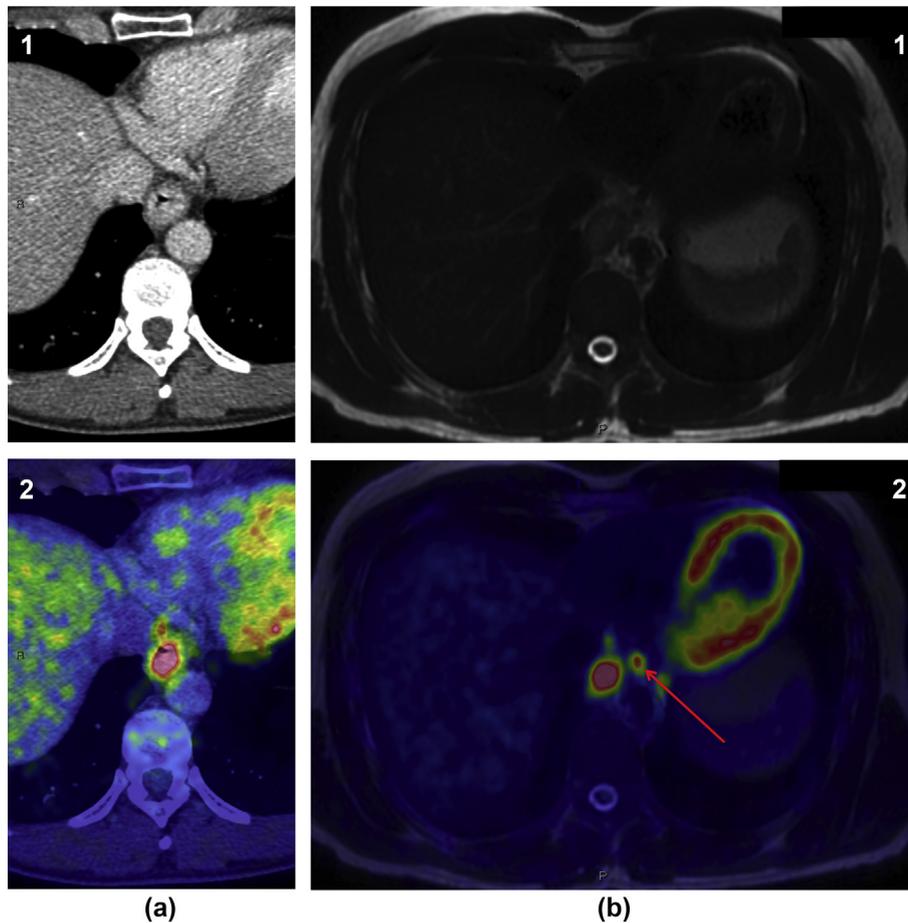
^{18}F -FDG-PET/CT and ^{18}F -FDG-PET/MRI in a patient with distal oesophageal cancer, where PET/MRI detects a suspected tumour-positive lymph node (arrow) that was not detected with PET/CT. (a1) CT image, (a2) PET/CT fusion image, (b1) MRI image, and (b2) PET/MRI fusion image.
